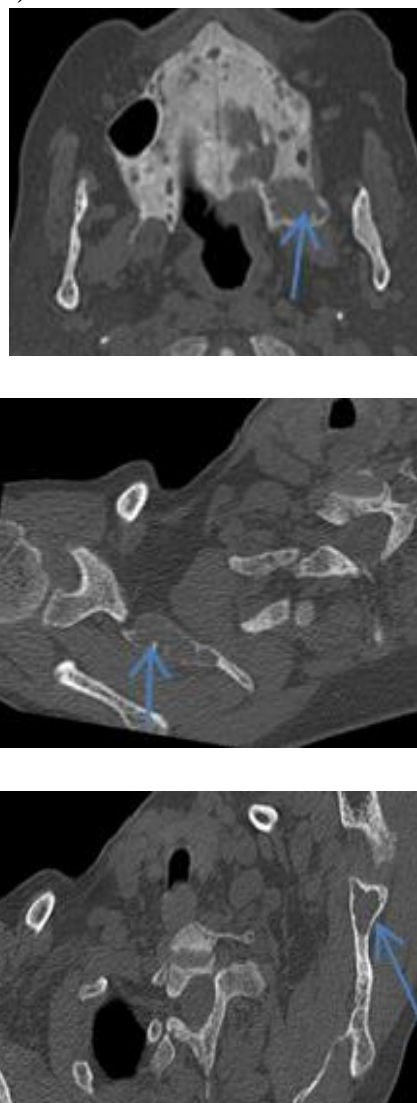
Axial CT scan showing lytic bone lesion of the hard palate and the scapulae
